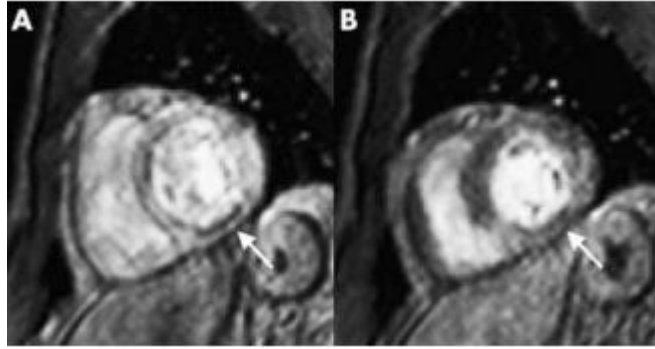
MRI perfusion images. (A) At rest condition, (B) Under stress condition [30]
